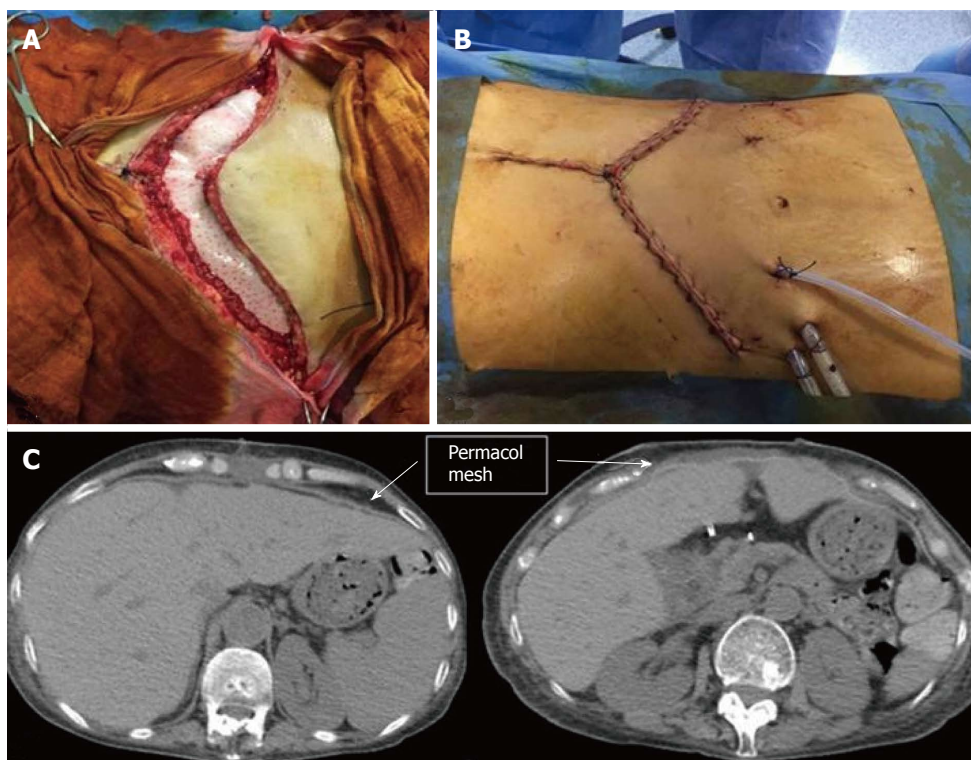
In order to prevent the onset of compartment syndrome, a temporary wound closure with Bogota Bag was performed. A: Implantation of Permacol™ mesh; B: Skin closure after Permacol™ mesh implantation; C: Computed tomography scan at 3 mo after abdominal wall repair (arrow: Biological prosthesis).
